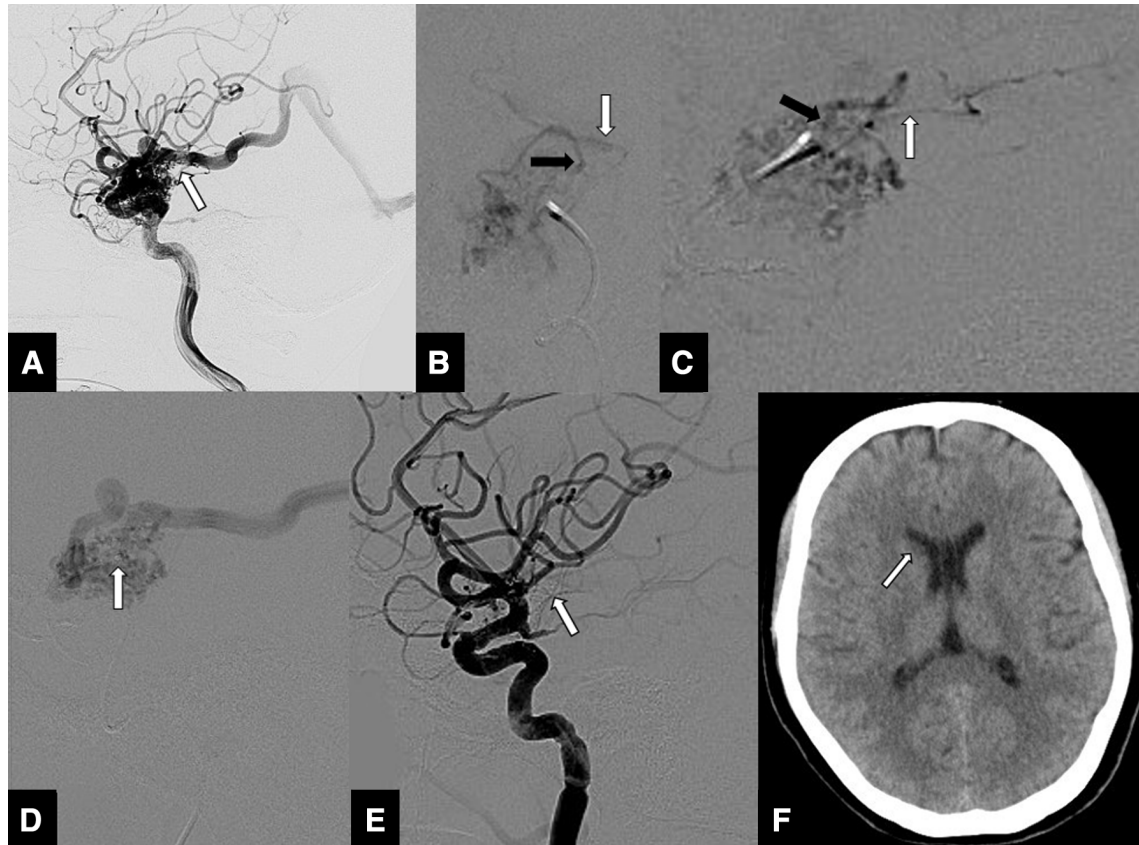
(A) Lateral view on right internal carotid angiography before embolization. AChA (white arrow). (B and C) Microcatheter angiography before embolization (right AChA). Frontal and lateral views. AChA (white arrow). Feeder (black arrows). (D) A microcatheter was unable to be guided beyond the cisternal segment. Microcatheter tip was positioned at a short distance from the orifice of the AChA. Normal perfusion of the AChA was unable to be confirmed, but the nidus was visualized. Microcatheter tip (white arrow). (E) Lateral view on right internal carotid angiography after embolization. The nidus was not visualized through the right AChA. AChA (white arrow). (F) CT after embolization. A small infarction was detected in the right caudate nucleus (white arrow). AChA: Anterior choroidal artery
